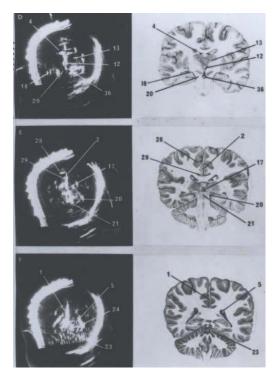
Left, grey scale images comparison of ultrasound anatomy with Echelscheimer's Brain Atlas (1972)
